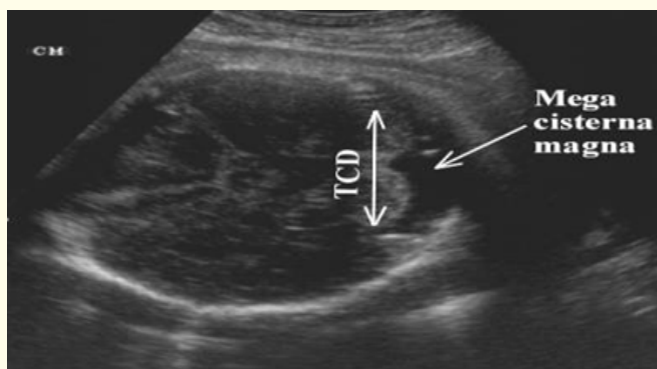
Fetal Ultrasound showing transcerebellar diameter.
